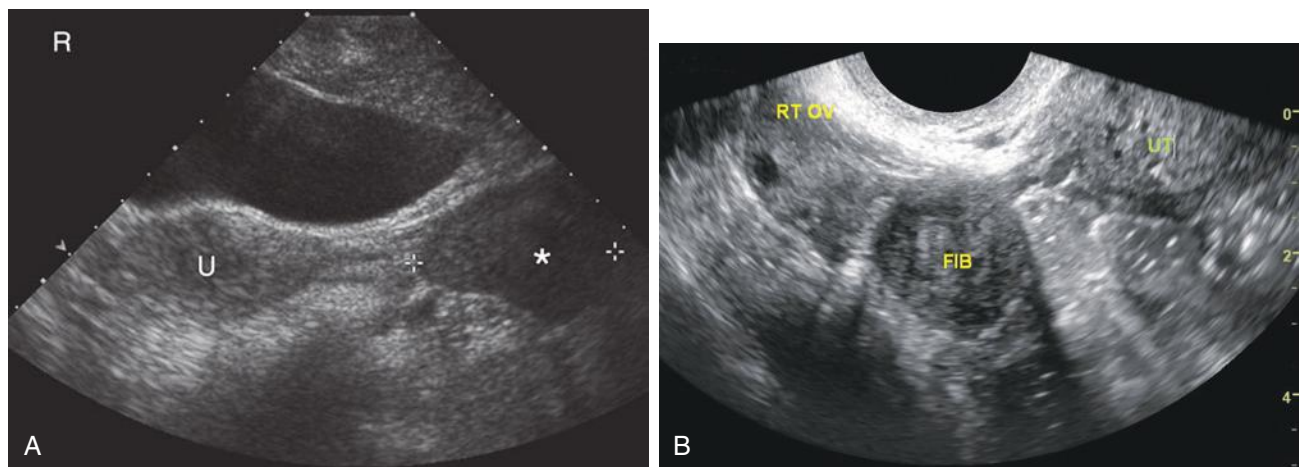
A, Transverse scan of the pelvis demonstrating a left adnexal solid mass (*asterisk*). Although the anatomic position might suggest an ovarian lesion, the solid nature of the mass should suggest the possibility of a broad ligament myoma, which was ultimately demonstrated on magnetic resonance imaging. U, uterus, R, right. B, Coronal transvaginal scan demonstrating a broad ligament myoma (FIB) clearly separate from the uterus (UT) and ovary (RT OV).
